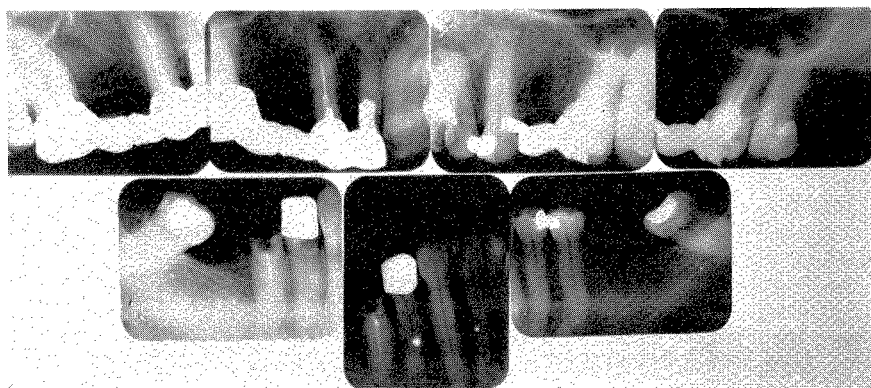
Roentgenograms taken in 1926 at the age of 44 years.
